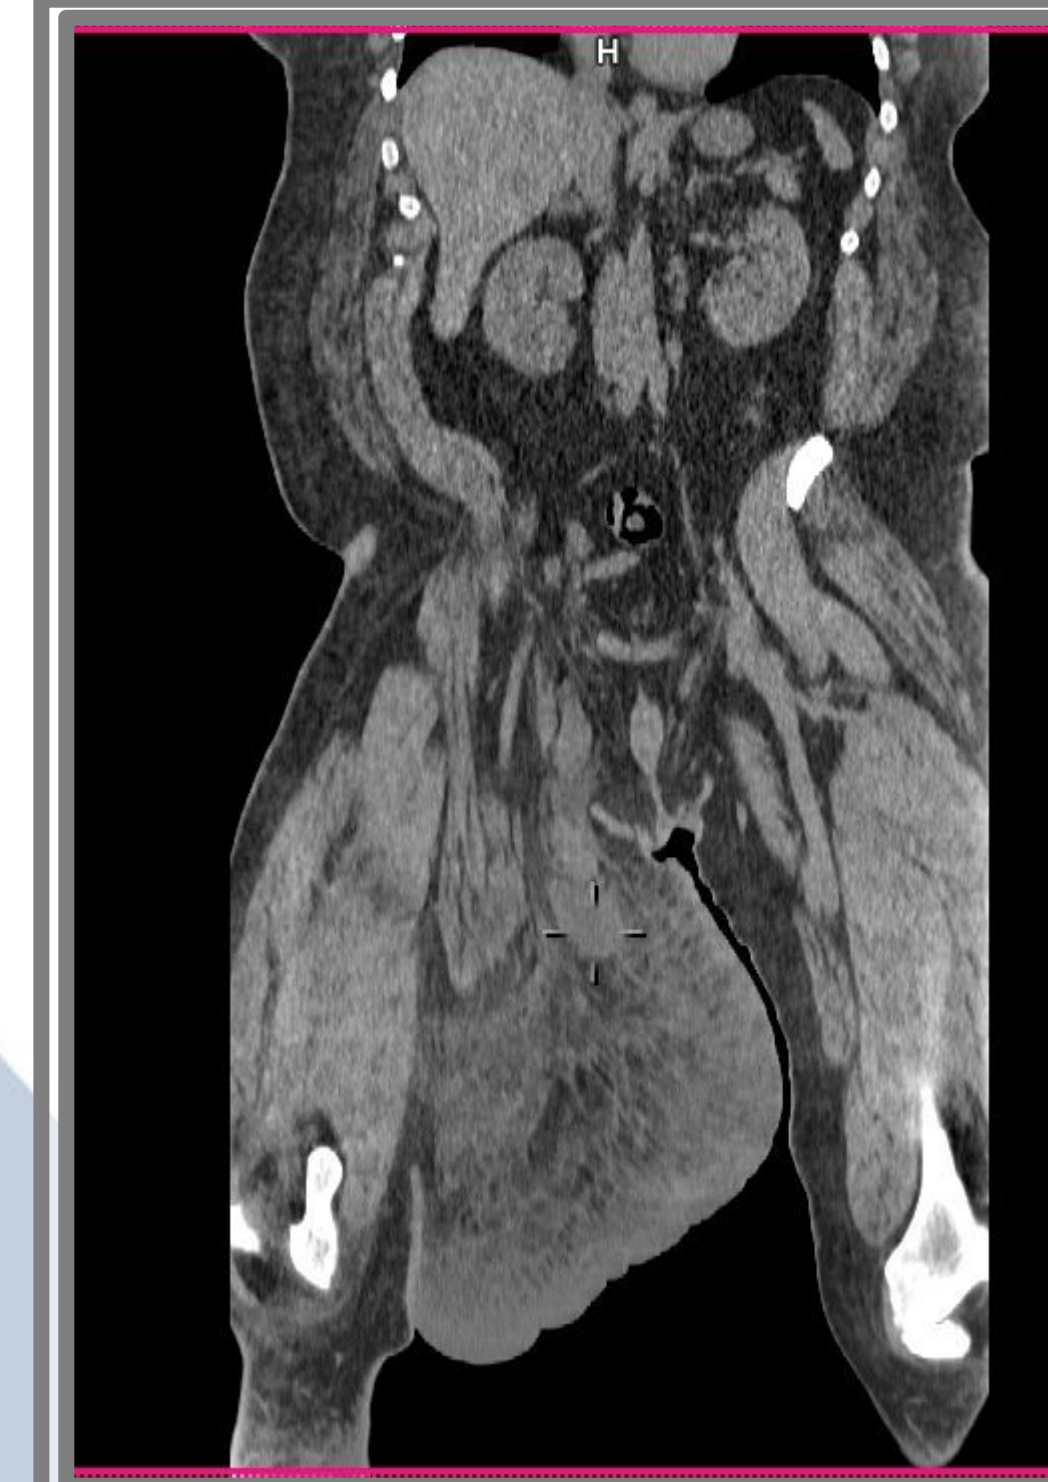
CT Abd/Pelvis: R inguinal lymphadenopathy and lymphedema
